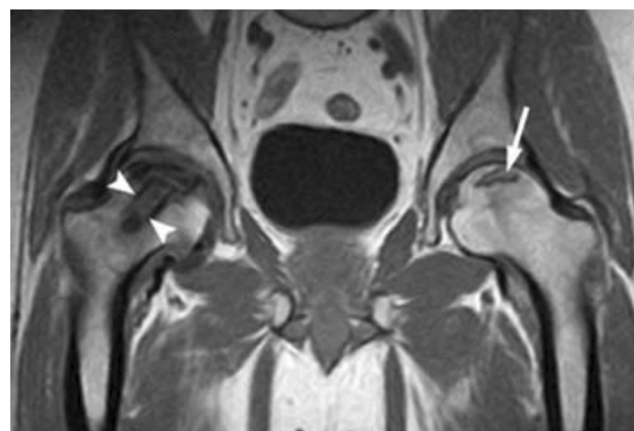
A coronal T1-weighted image of the hip with avascular necrosis which received core decompression (the right hip, arrowheads) and occult AVN (the left hip, arrow) with subchondral radiolucency, crescent sign. [David S. Levey. MRI Web Clinic, AVN of the Hip. November 2005]
